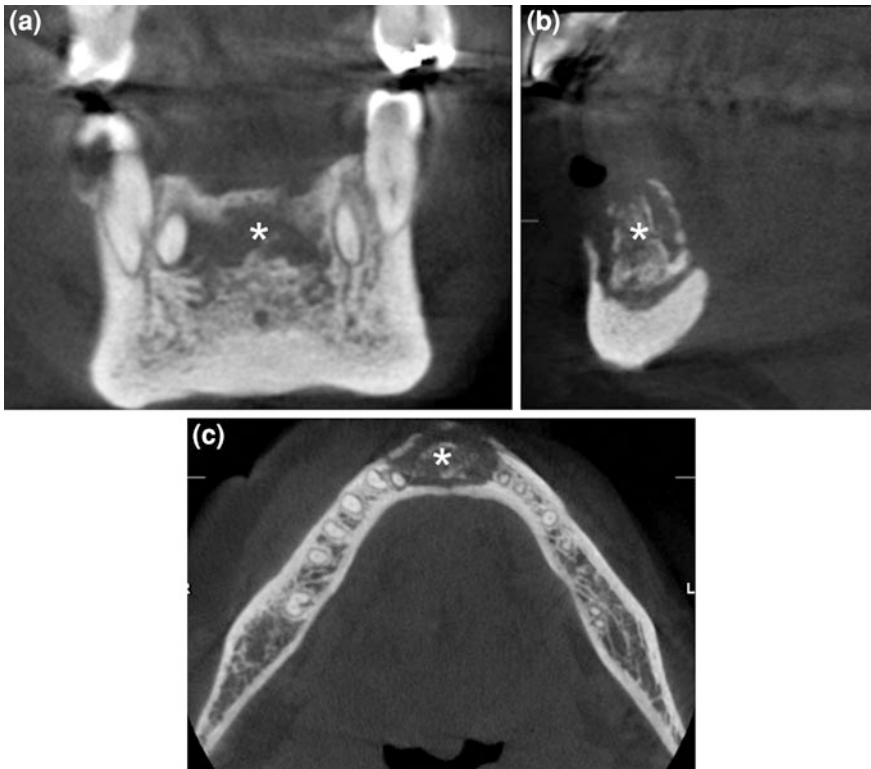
CBCT coronal (a), sagittal (b) and axial (c) scans showing mandibular bone defect due to bisphosphonate-related osteonecrosis that appears like a radiolucent lesion with sclerotic margin (*)
